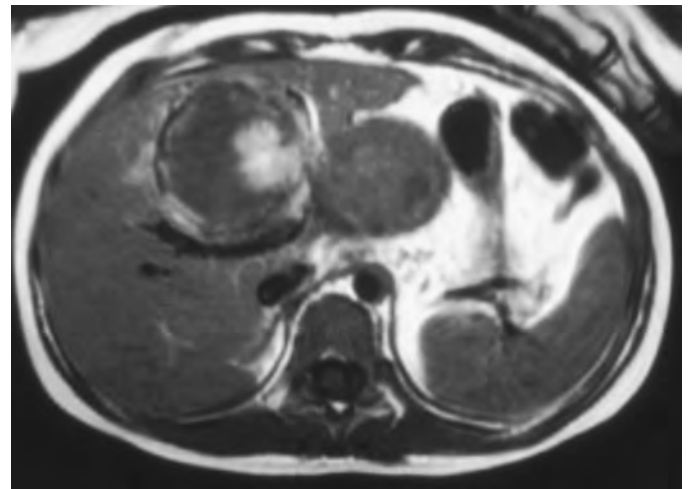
Undifferentiated embryonal sarcoma. Axial T1-weighted MRI through the upper abdomen in an 8-year-old girl demonstrates a bilobed mass arising from the left hepatic lobe.
